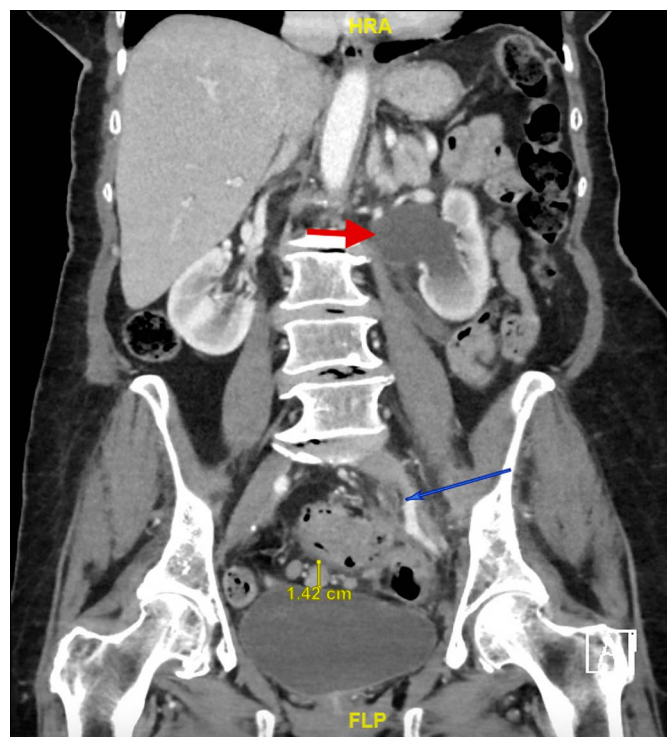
Abdominal and pelvic computed tomography showing a short segment of sigmoid colonic wall thickening and mild stranding in the adjacent fat and adjacent mesenteric lymphadenopathy. There is also evidence of left-sided moderate hydronephrosis, without renal calculi noted, to the level of the colonic wall thickening and left psoas abscess concerning for fistulous tract. Midsigmoid colonic wall thickening (blue arrow) with upstream dilation of the ureter and renal calyx (red arrow).
